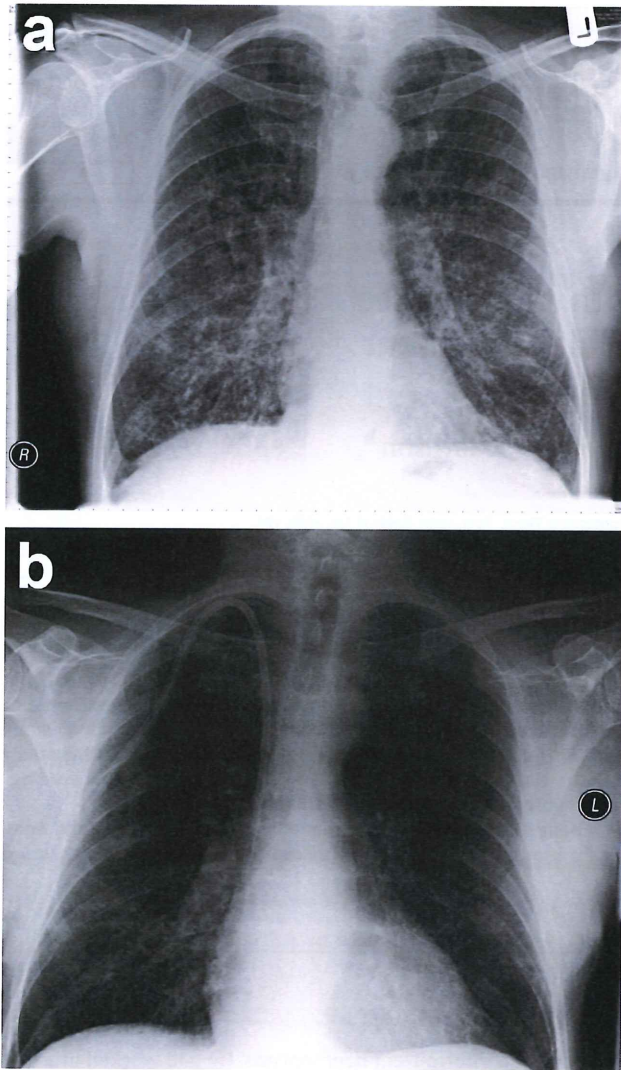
Chest radiograph at presentation (a) and 2 months later (b).
